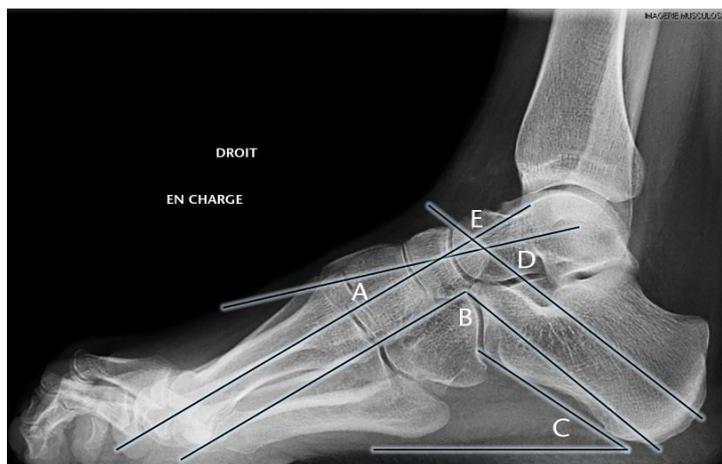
Radiographic angles on lateral standing radiograph. a) Talo-first metatarsal angle (Meary's angle); b) Djian-Annonier angle less than 120° in cavus foot; c) calcaneal pitch; d) talocalcaneal angle; e) first metatarsal-calcaneal angle (Hibb's angle)⁽⁶⁾.
